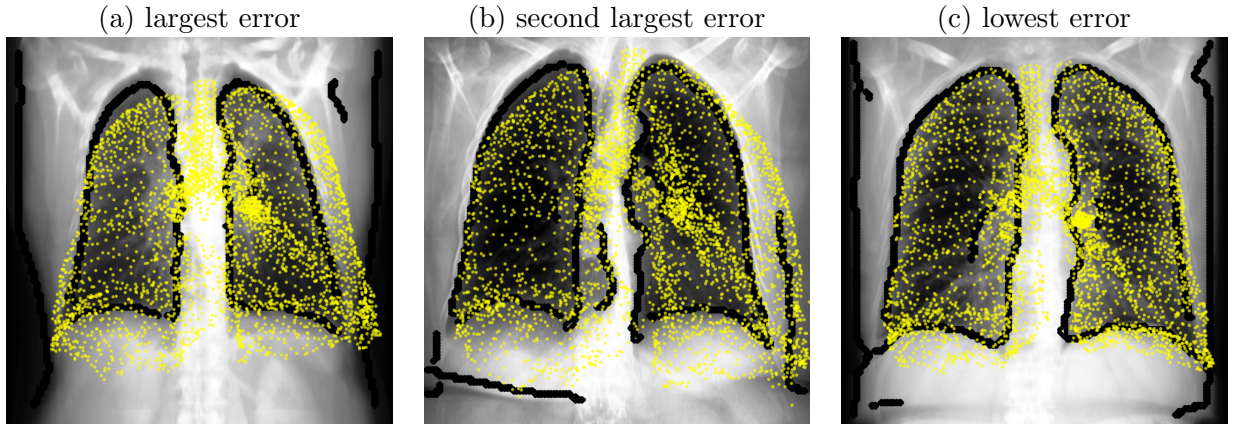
Example of fitted SSAM compared to projection and lung outline for two largest lung space volume errors in the LUNA16 dataset. Yellow markers are output landmarks from the SSAM, and black markers represent the X-ray edges detected by the Canny edge map described in Section 2.2.1. Panels show (a) the largest error, (b) second largest error and (c) the lowest error. In (a) the right lung error was 31% and left lung error was 42.6%. In (b) the right lung error was 15.5% and left lung error was 38.3%. In (c) the right lung error was 1.8% and left lung error was 0.06%.
